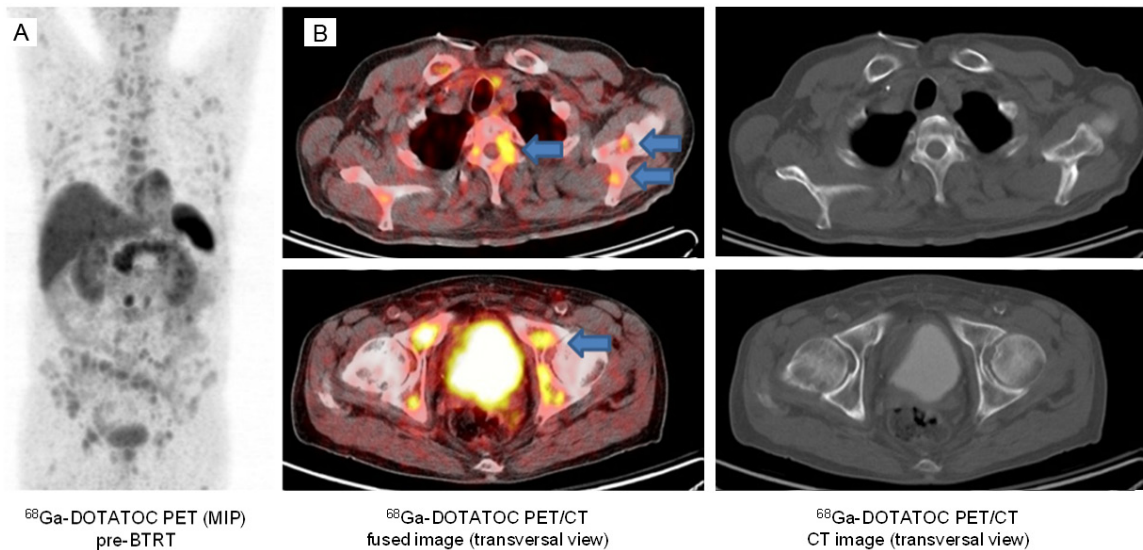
Images of a patient with disseminated PRRT-refractory bone metastases. The absence of corresponding morphologic correlates for several findings of ⁶⁸Ga-DOTATOC PET (arrows) supports the implementation of functional somatostatin receptor imaging for a more accurate evaluation of bone metastases of NET. A: Maximum-intensity-projection ⁶⁸Ga-DOTATOC PET images (coronal view); B: Fused PET-CT (left) and corresponding CT images (right) of the same examination.
